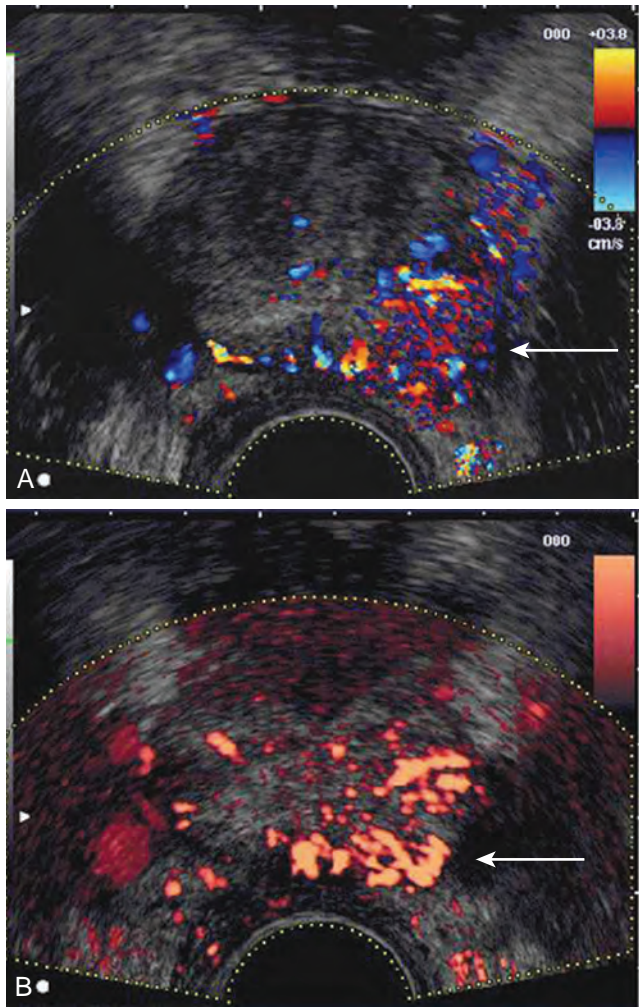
Color Doppler (A) transrectal ultrasonography (TRUS) and power Doppler (B) TRUS identify a Gleason 4 + 4 = 8 adenocarcinoma (arrows) in the left mid-gland.
